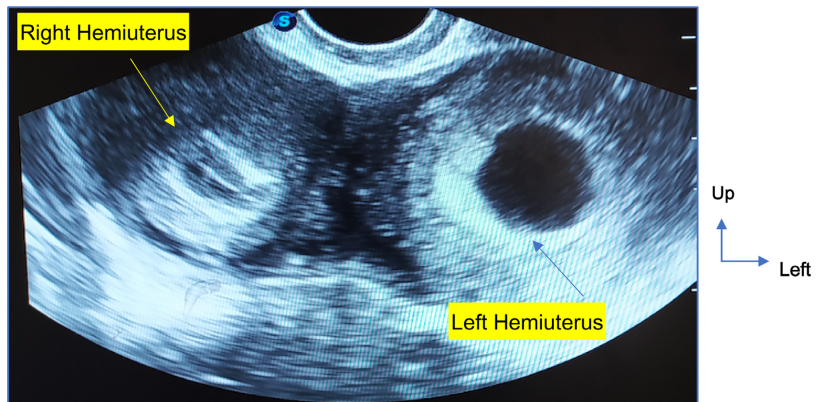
Pelvic ultrasound with two uterine cavities. On the left a clear egg of 7SA and on the right an incomplete abortion (Picture Hôpital Principal de Dakar).
